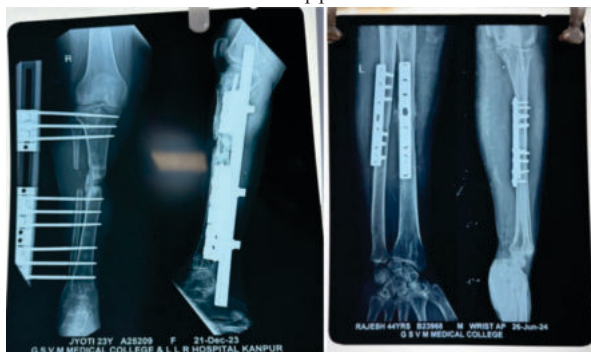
Radiographic images demonstrating external fixation using the LRS technique and internal fixation using plating
